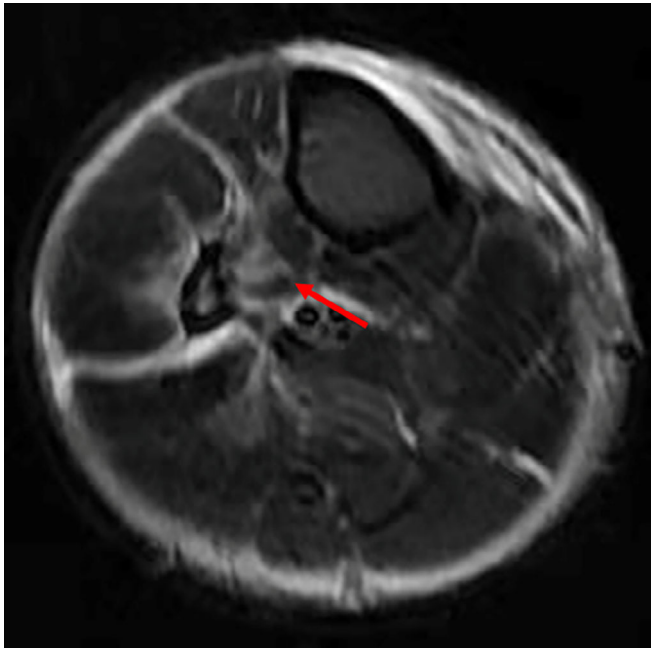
The axial MRI (cross-sectional FS T2WI images) of the proximal fibular fracture site showing rupture of the interosseous membrane and partial rupture of the posterior tibial muscle (red arrow: rupture of the interosseous membrane and partial rupture of the posterior tibial muscle)
